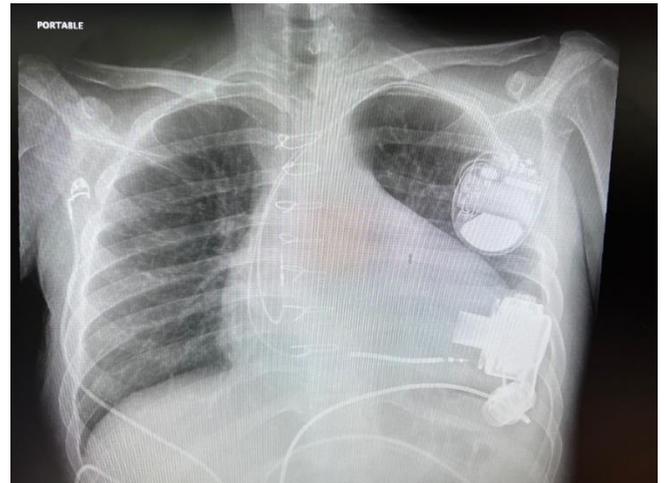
Chest X-ray post LVAD insertion with s/p ppm.
